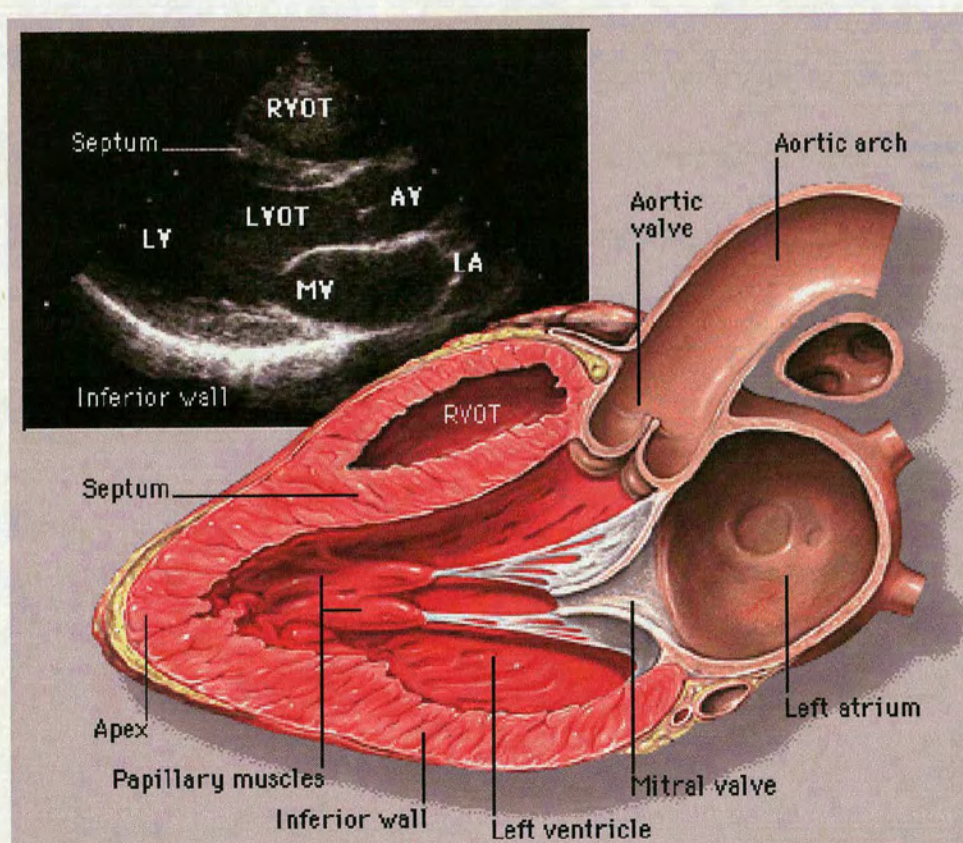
Example echocardiogram showing left parasternal, long-axis view [1].
